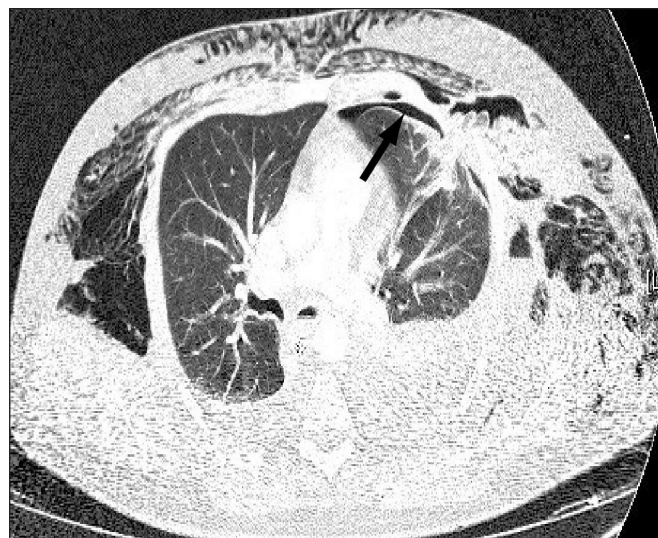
Computed tomography scan showing associated pneumothorax (arrow).
